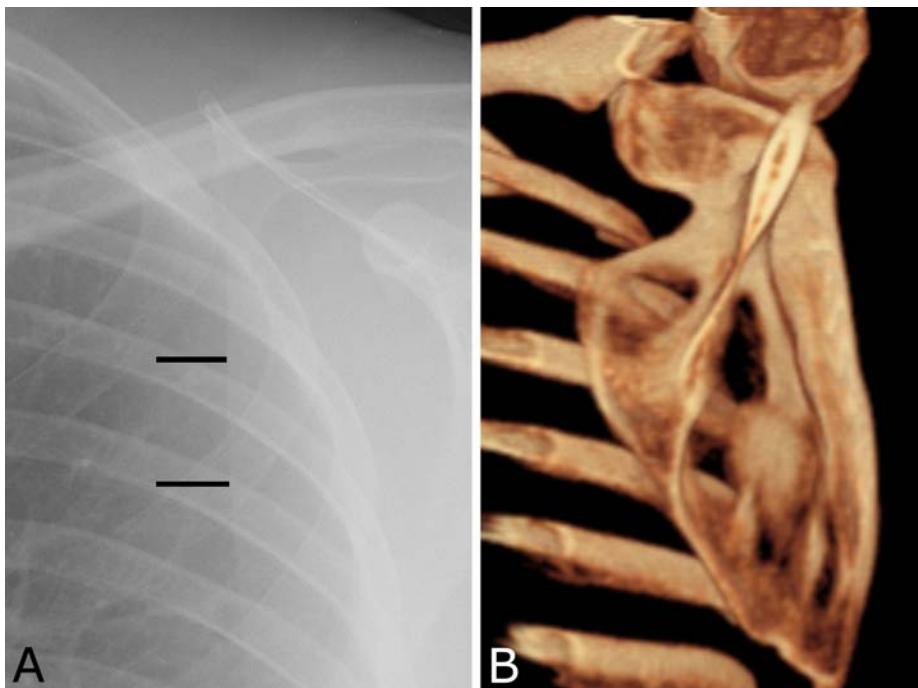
Scapula. A. Frontal radiograph. The scapula will overlap the lung field to various degrees depending upon how the patient has been positioned. Recognize the medial border of the scapula (black lines). B. Volume rendered CT shows the scapula in relationship to the adjacent ribs.
